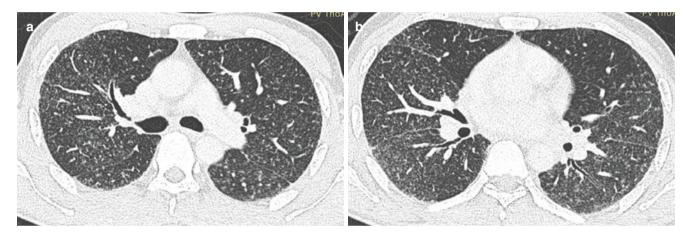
Random nodules in miliary tuberculosis. (a, b) Axial CT images show innumerable miliary nodules without any definite pattern of localization
